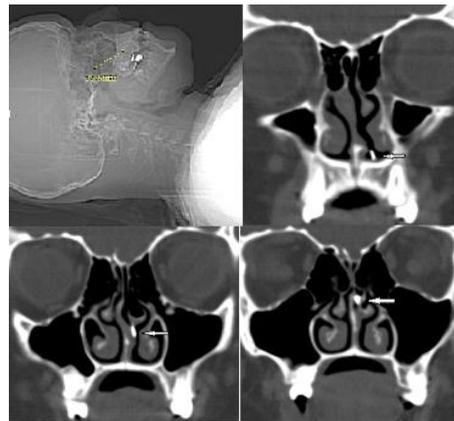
Paranasal CT scan (Localizer and coronal scan): white arrow: foreign body (long pin).
